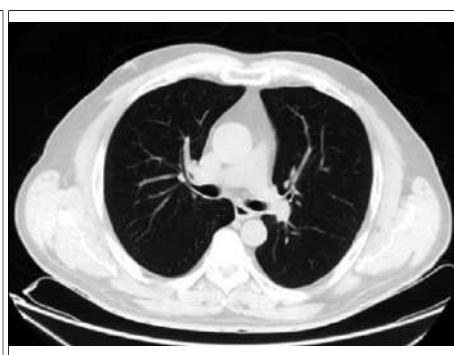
CT scan chest after 12 months showing complete resolution of the lung atelectasis and the tumor-like lesion of the right upper lobe.
